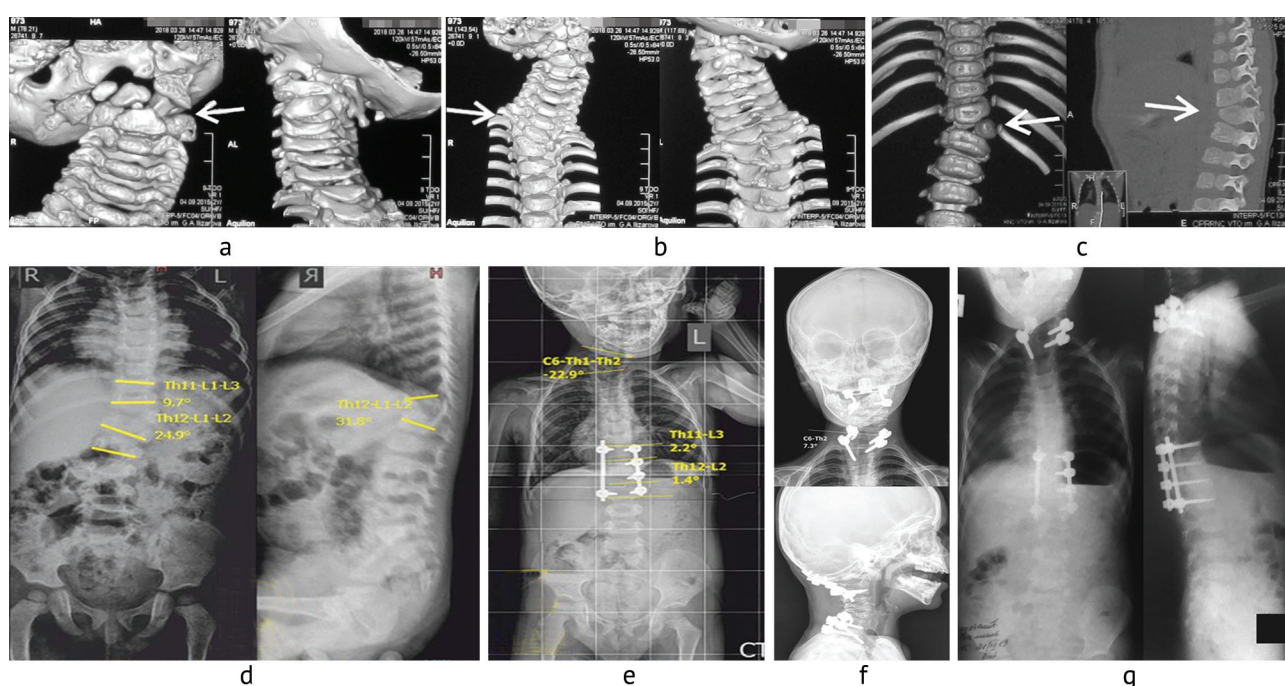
Radiographs and CT scans of a patient aged 1 year 11 months with multiple anomalies and segmentation of the cervical and thoracic spine
